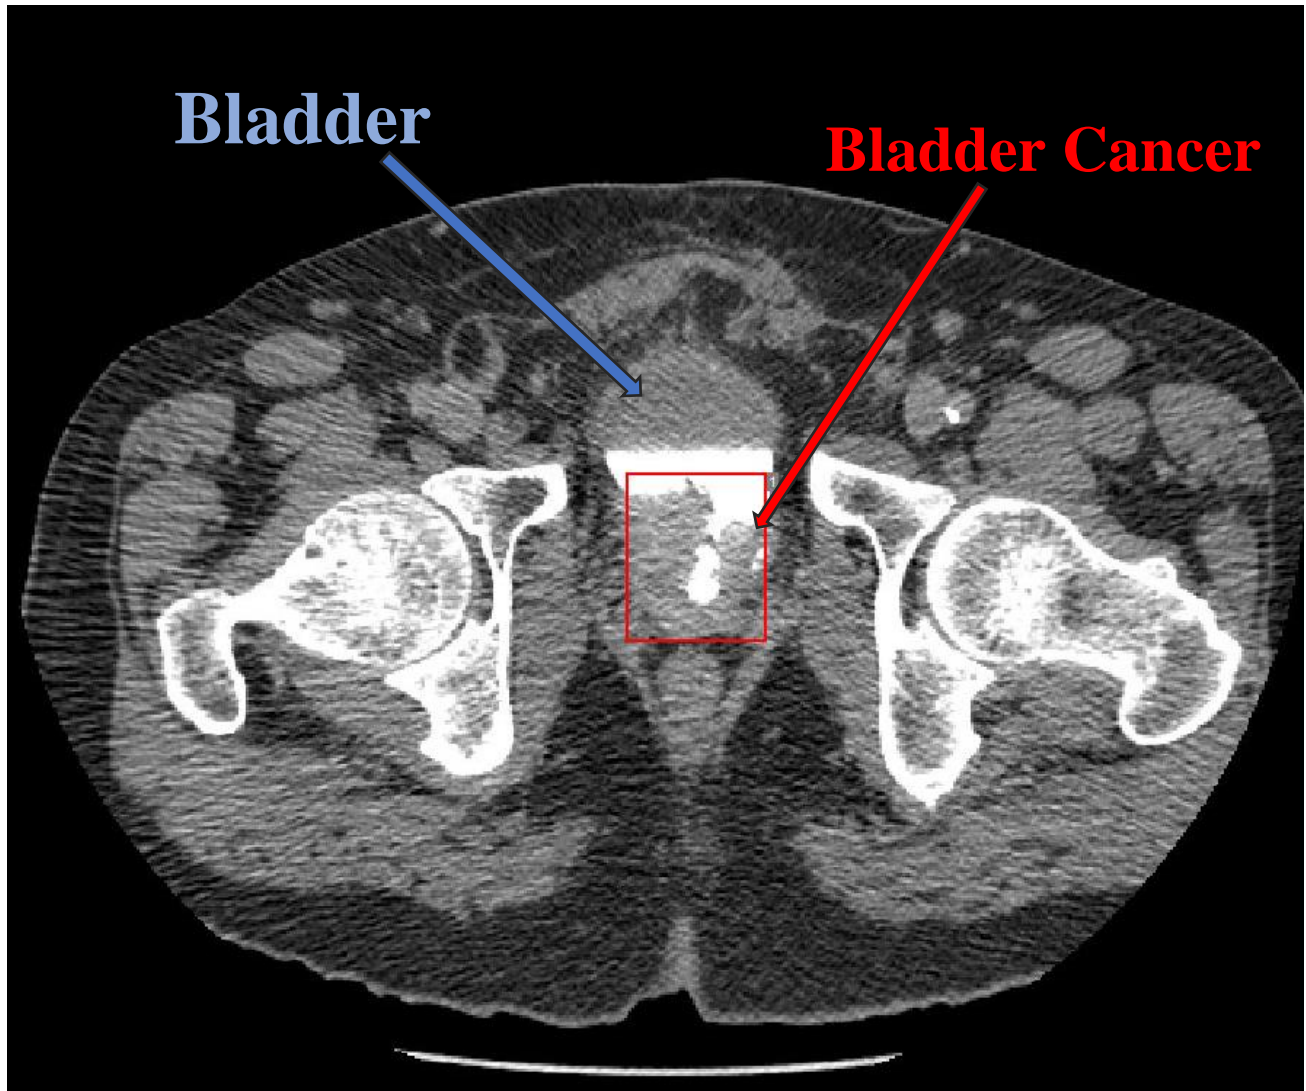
Cross-sectional image, CT slice, of the urinary bladder. The bladder cancer (Stage T1) is enclosed by the red box provided by an experienced abdominal radiologist.
